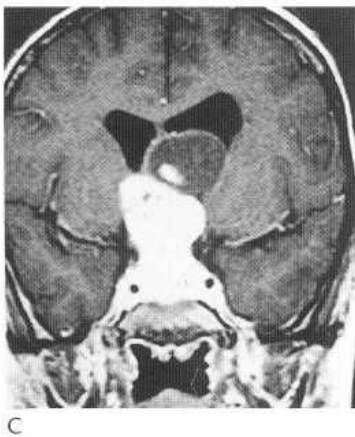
Axial CT (A) and T_2 -weighted MRI (B) showing a largely cystic lobulated suprasellar mass. There is a small focus of calcification posteriorly within the lesion and appearances are those of a craniopharyngioma. The coronal T_1 postcontrast image (C) is of another patient with a craniopharyngioma which has both cystic and solid enhancing components.
